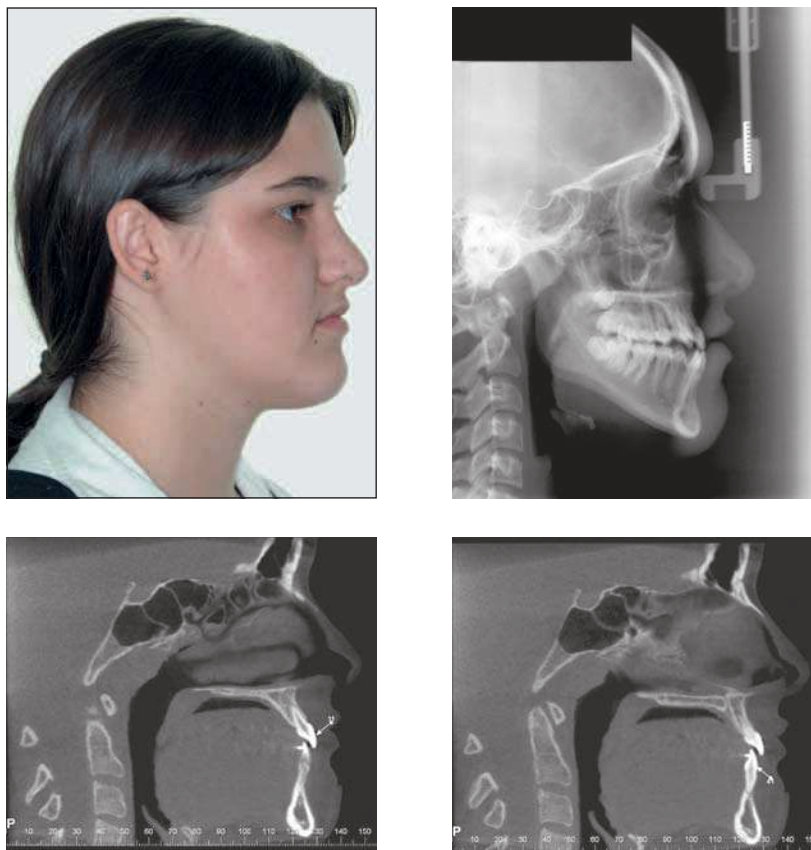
Patient with pattern III, Class III malocclusion, prognathism with CT image clearly showing the limitations of bone support for all incisors (teeth 21 and 31, images obtained by sectioning the center of the clinical crown) and their respective basal bones.
